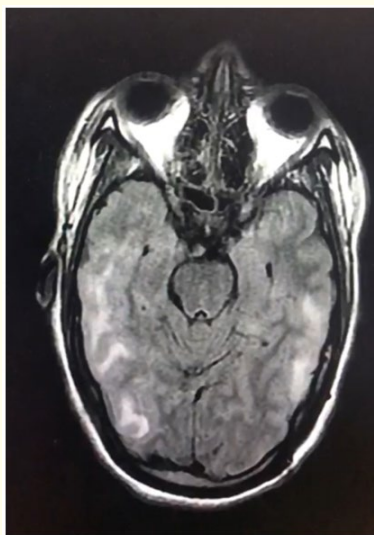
Encephalic magnetic resonance imaging (MRI), axial section, T2 flair and diffusion sequence: bilateral, poorly systematized frontoparieto-occipital hypersignals.
